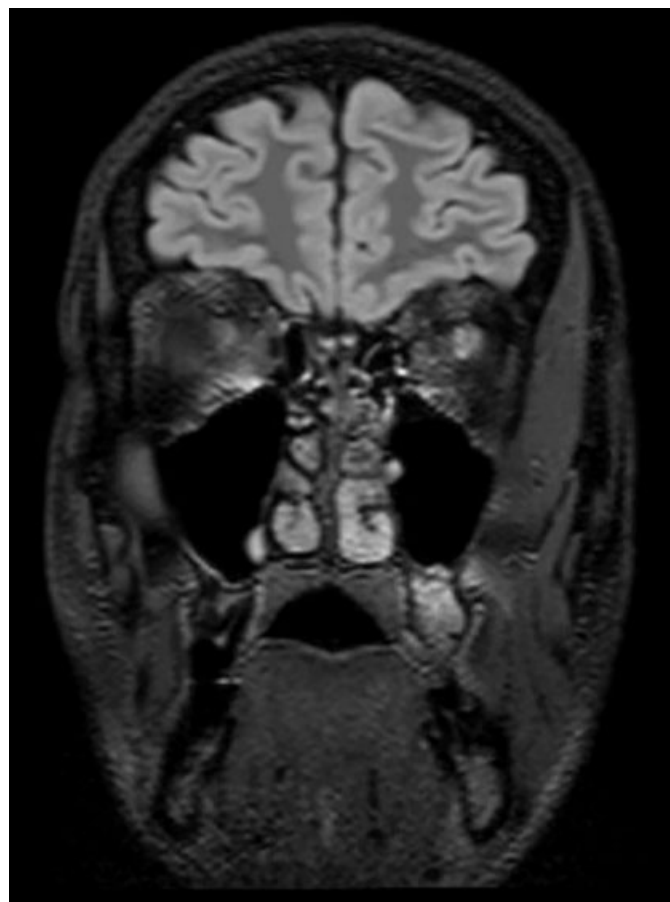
MRI FLAIR of case 3: Edematous alterations in the perioptic fat tissue around the retrobulbar left optic nerve. Increased FLAIR-signal of the left optic nerve.
